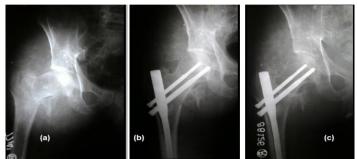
(a) Post traumatic X-ray right hip joint in AP view shows Type A-II fracture of proximal femur (b) Immediate post-operative X-ray (c) Final follow up X-ray with good results.
